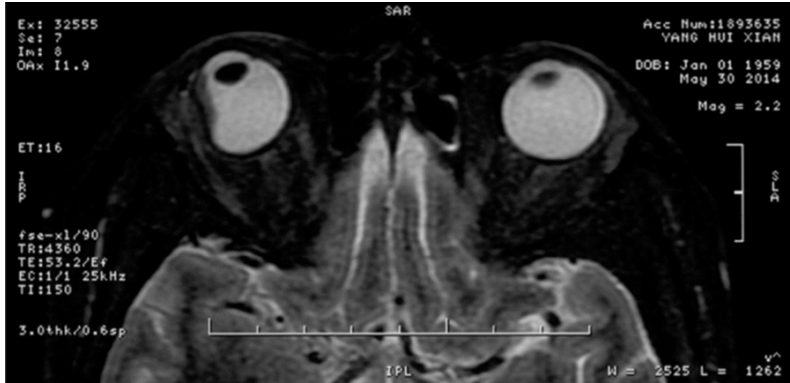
Plain and contrast enhanced MRI of the orbit showed an upper eye ring-occupying lesion outside of the eyeball.
